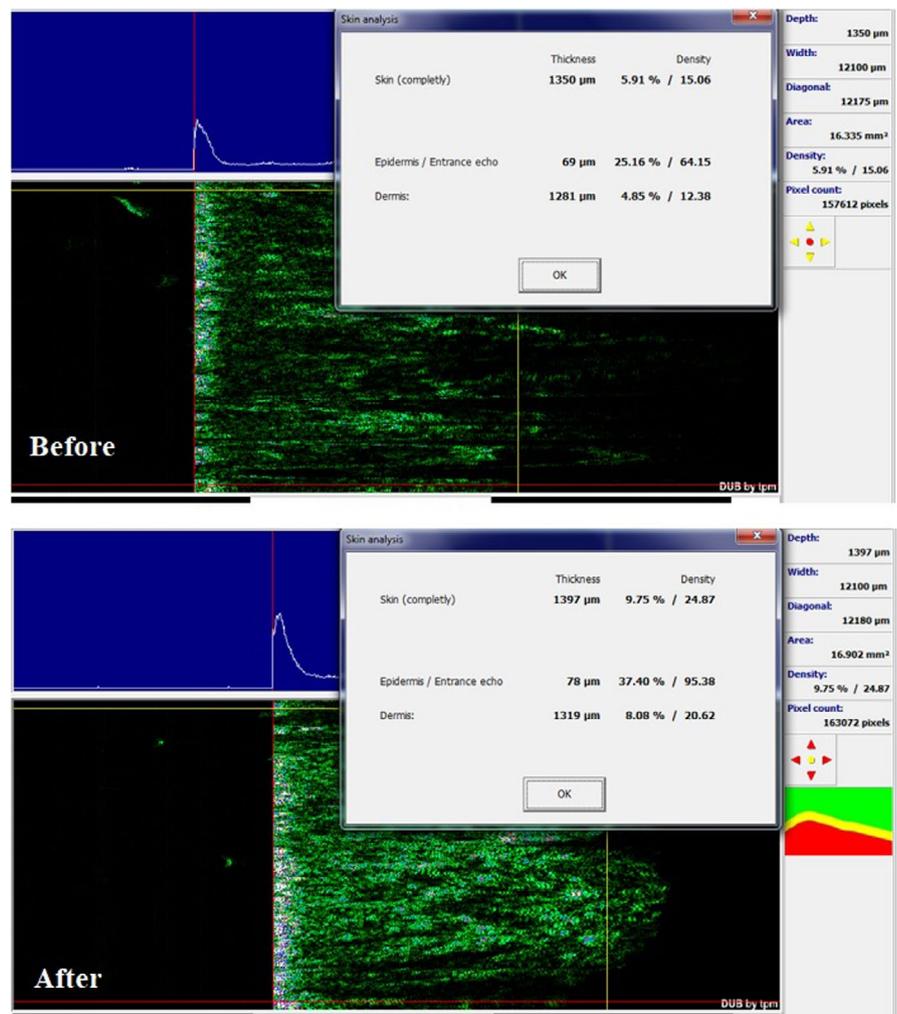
Skin ultrasonography in the patients before and after Endolift Laser treatment
